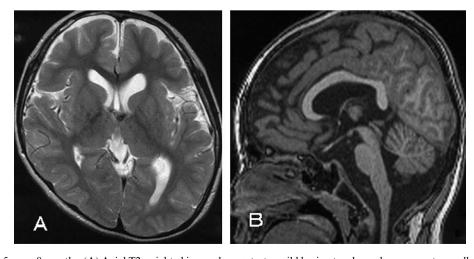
Brain MRI at 5 years 8 months. (A) Axial T2 weighted image demonstrates mild brain atrophy and cavum septum pellucidum. (B) Sagittal T1 weighted image demonstrates normal structure of the corpus callosum.
